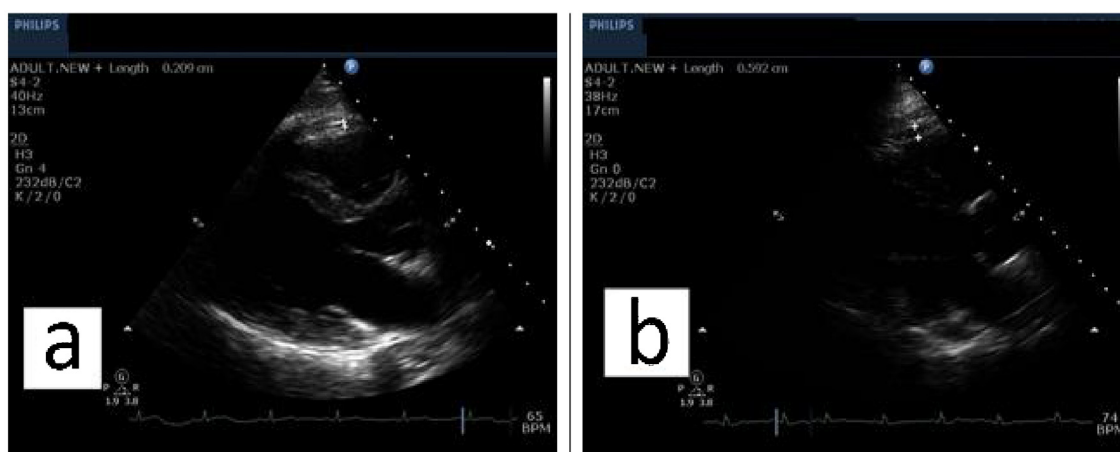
Examples of estimation of Epicardial Adipose Tissue thickness (EATT) by Trans Thoracic Echocardiography: a) Normal EATT. b) Increased EATT.
